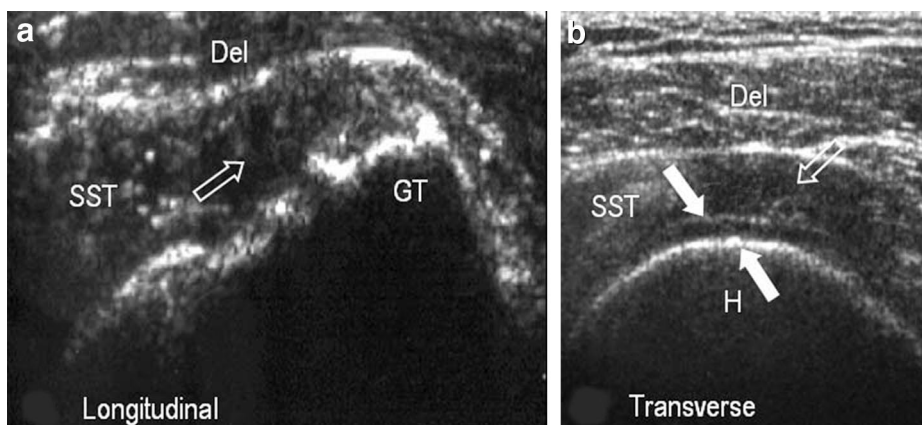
Full-thickness tear of the supraspinatus tendon. a, Longitudinal sonogram depicting a focal hypoechoic defect (open arrow) with deltoid muscle (Del) herniation from above. Exaggeration of cartilage reflection is seen here in the absence of an overlying tendon. Cortical irregularities are seen at the greater tuberosity (GT). b, Transverse sonogram showing double-cortex sign (arrows), representing the articular hyaline cartilage above and the cortex of the humeral head below.
